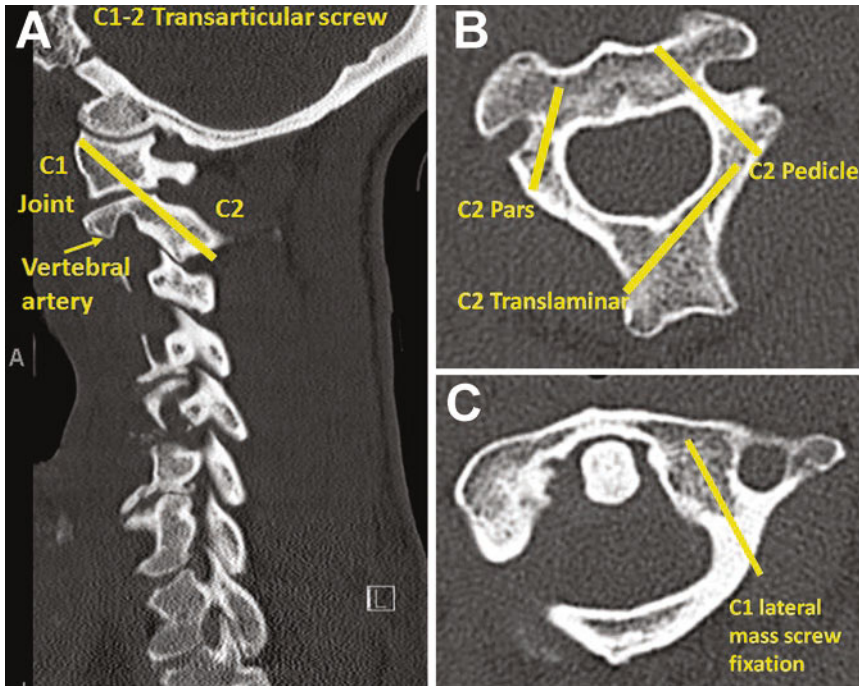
(a) Axial CT image cut through C2 with representative lines depicting the trajectory for each of the screw types (pars, pedicle, and translaminar). (b) Sagittal CT image depicting the trajectory for a C1-2 transarticular
